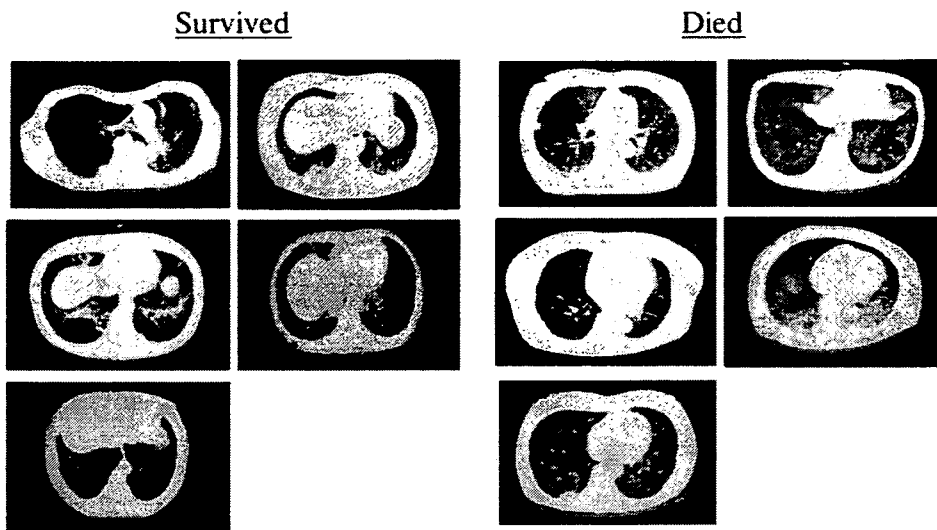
Representative chest CT images of patients with A/SIP at the commencement of a combination treatment regimen comprised of high-dose corticosteroids, CsA and IV-CYC.
